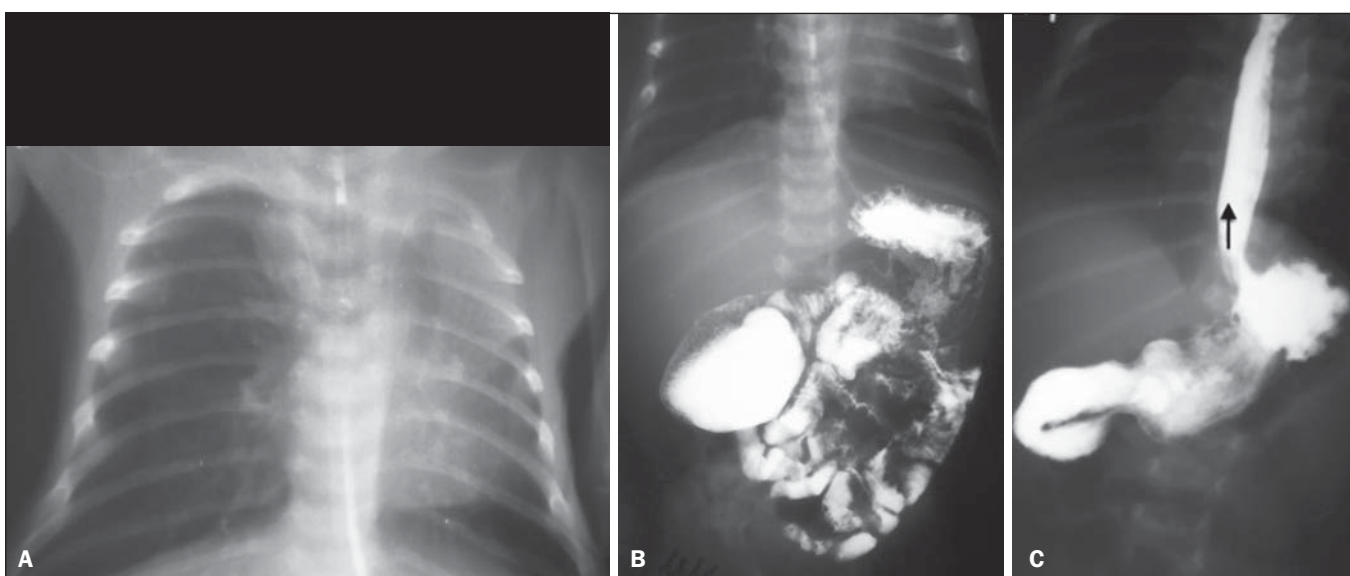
A neonate with Down syndrome and respiratory symptoms. A: Anteroposterior chest radiography showing left lung with decreased volume and transparency. Fading of the left cardiac silhouette indicates upper lobe atelectasis. B: EGDS. Small bowel transit shows partial obstruction at the level of the second duodenal portion, with appearance suggestive of duodenal diaphragm (windsock sign). C: Secondary gastroesophageal reflux.
